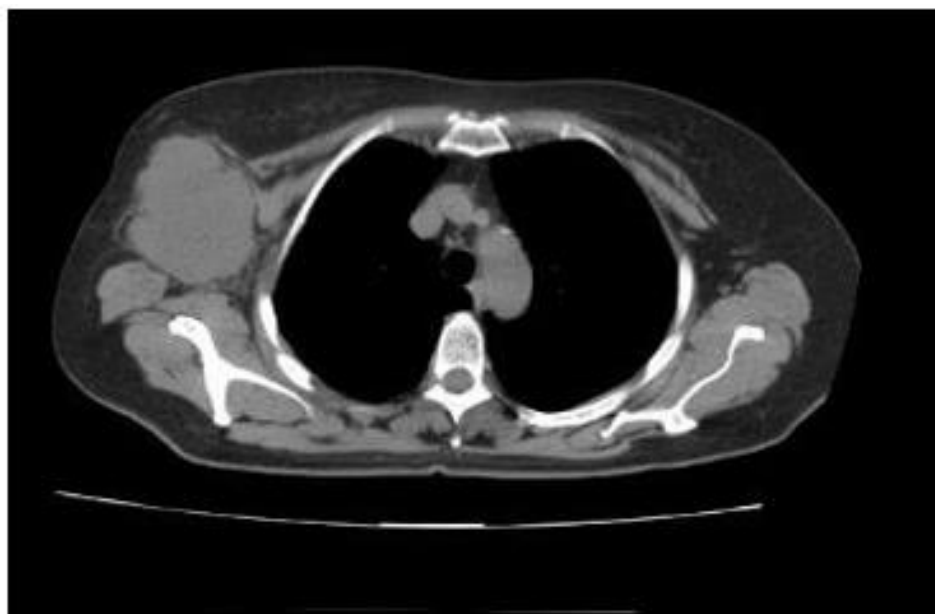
Chest CT scan with contrast: Right axillary mass measuring 60 x 76 mm.
